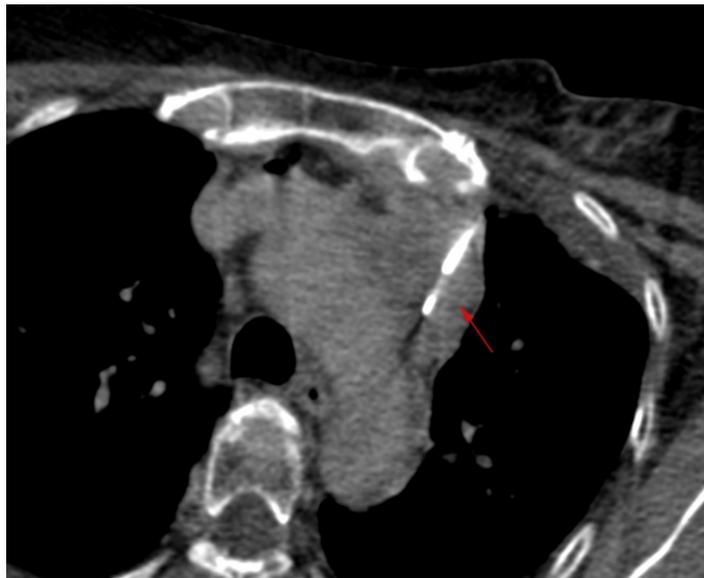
CT guided biopsy of the left para-aortic node, using a left para-costal approach.
